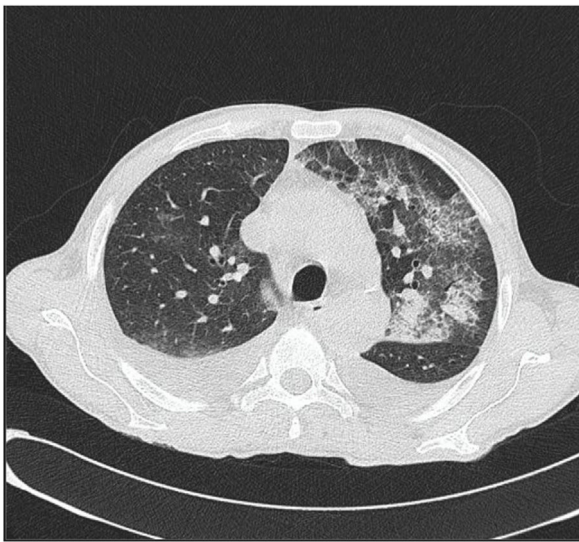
Chest and abdomen computed tomography showing bilateral infiltrates in lungs.
